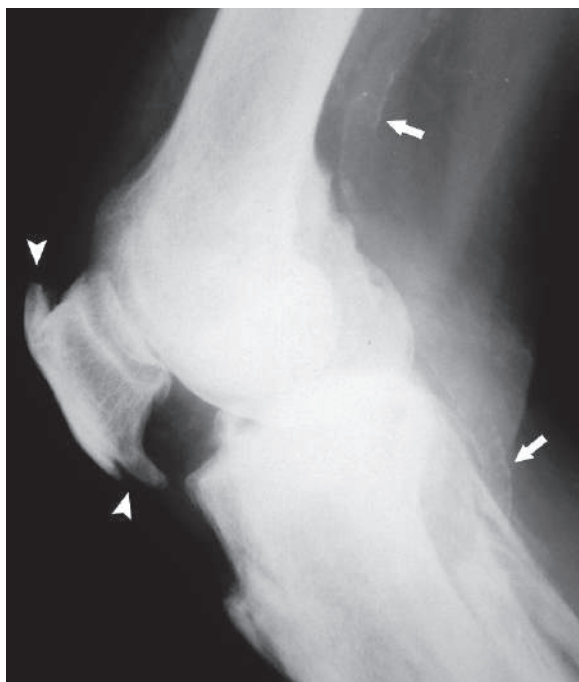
Lateral knee radiograph of the same patient shows diffuse sclerosis with sclerosis and osteophytes formation of the quadriceps and patellar tendons insertion at the superior and the inferior poles of the patella (*arrowheads*). Sclerosis of the popliteal vessels can be observed too (*arrows*)
